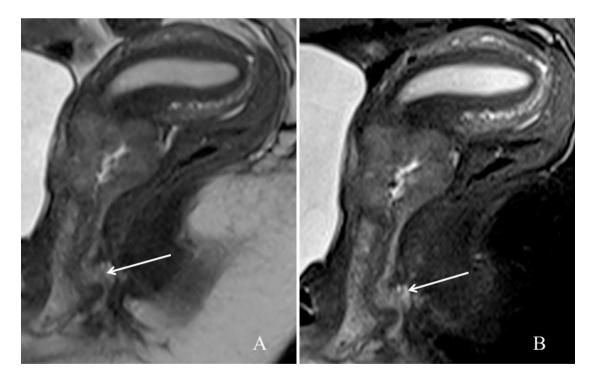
Sagittal T2 (A) and STIR (B) MRI showing extension of cervical mass to lower third of vagina (white arrow) staged as IIIA.
